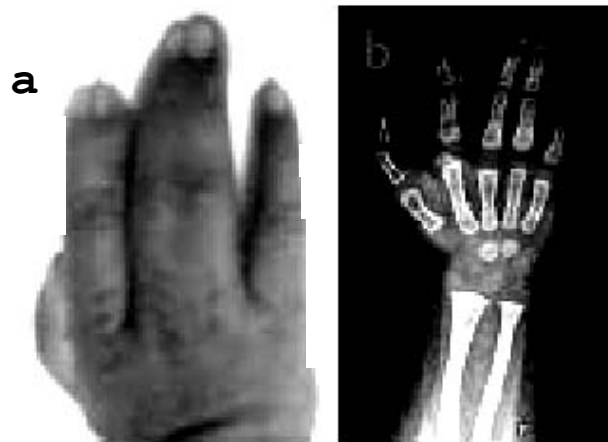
Figure a is a photograph of patient's right hand and Figure b is radiograph of patient's right hand
